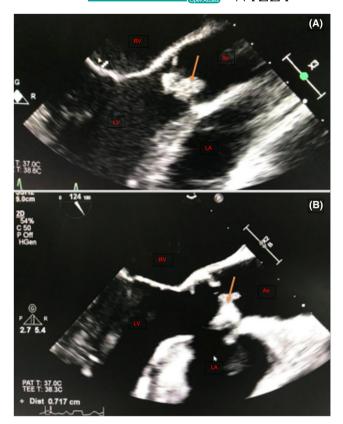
Transesophageal echocardiogram done in January 2023. A transesophageal echocardiogram showing two 6mm mobile slender echocardiographic densities attached to the ventricular surface of the aortic bioprosthetic valve leaflets. Orange arrows indicate the vegetation. Ao, aortic outflow tract; LA, left atrium; LV, left ventricle; RV, right ventricle.
